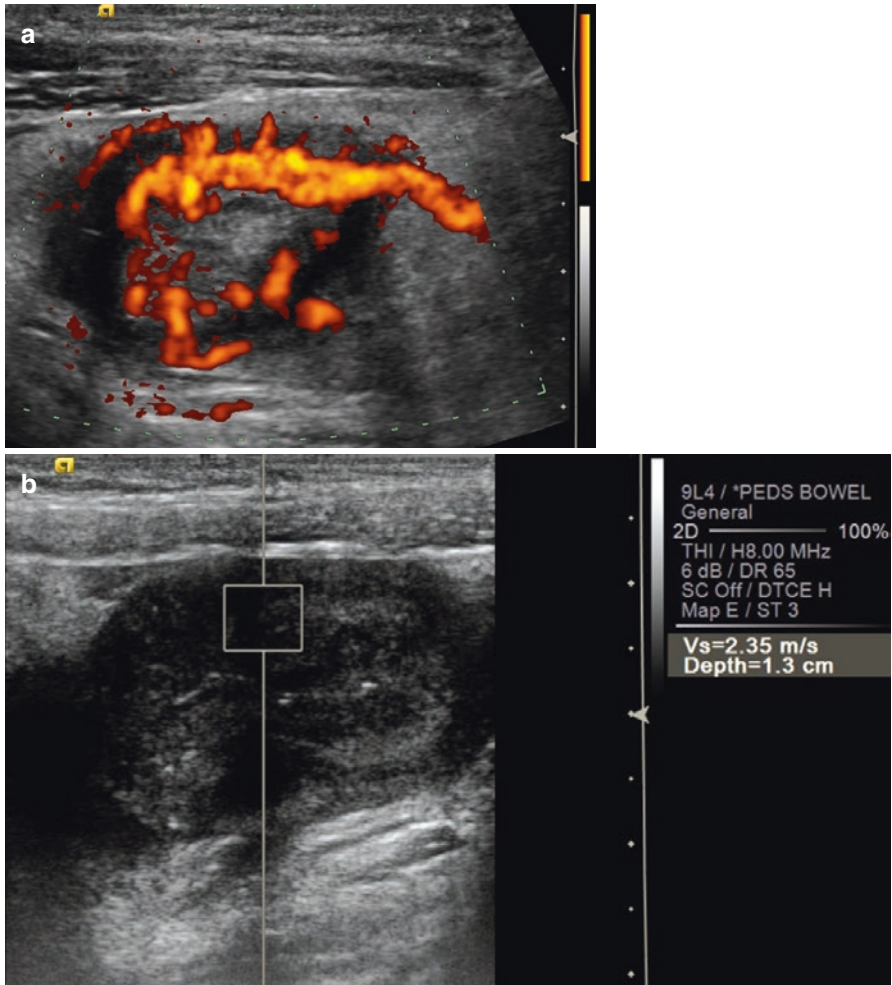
Teenage boy with stricturing ileal small bowel Crohn's disease. (a) Power Doppler image in the region of the small bowel stricture shows markedly increased blood flow, indicative of substantial active inflammation. (b) Point shear wave speed measurement from the stricture measures 2.35 m/s, suggesting abnormal stiffening of the bowel wall and likely transmural fibrosis
